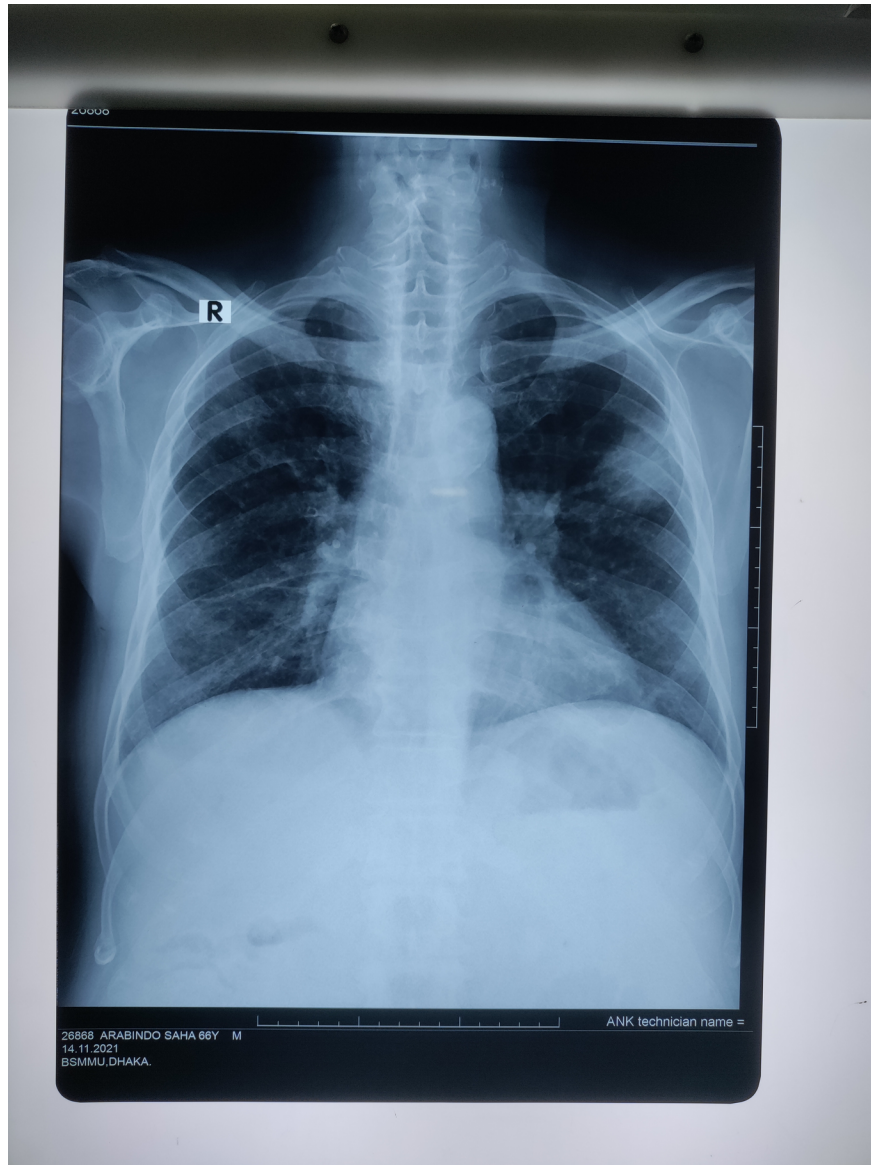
chest x-ray after one month of treatment with oral posaconazole showing near complete resolution of lung lesions
